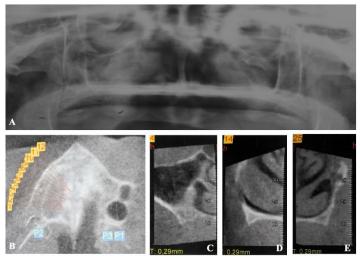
Pre-operative Orthopantomography (OPG) (A) and CBCT series revealing bone atrophy (Cawood and Howell class IV). (B) axial section. (C) section 4 (right maxilla). (D) section 14 (pre-maxilla). (E) section 25 (left maxilla).
